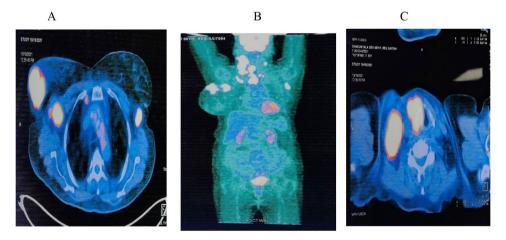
A PET -CT images showing involvement of axillary lymph nodes. B involvement of cervical lymph node (level 2 to 5). C whole body view
